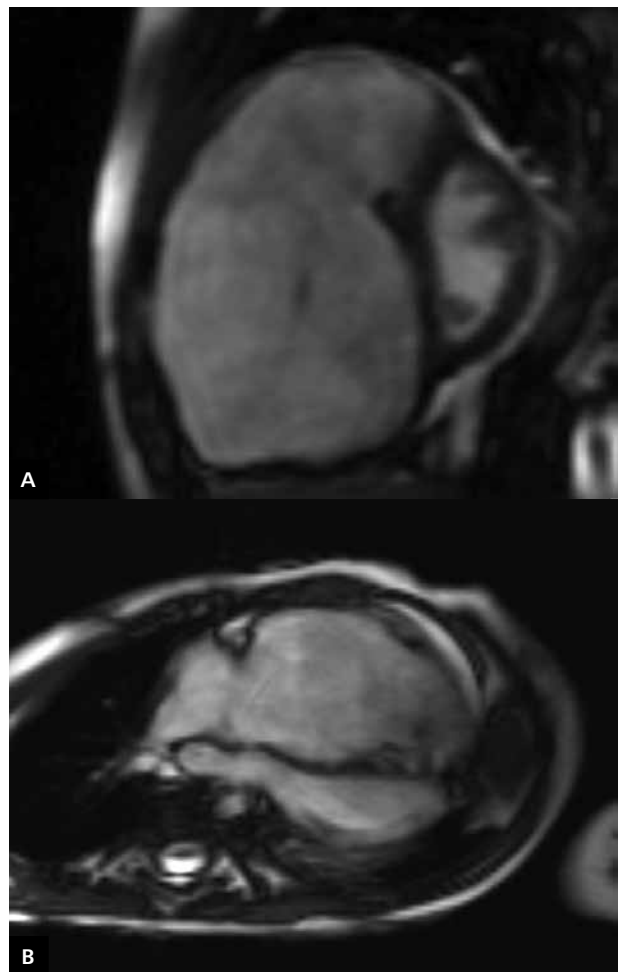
Cardiac magnetic resonance images in a patient with arrhythmogenic right ventricular cardiomyopathy; A. Short-axis view in end-systolic phase, cine SSFP sequence. Markedly enlarged right ventricle with the presence of regions of dyskinesia in the right ventricular inferior wall; B. Four-chamber view, cine SSFP sequence
